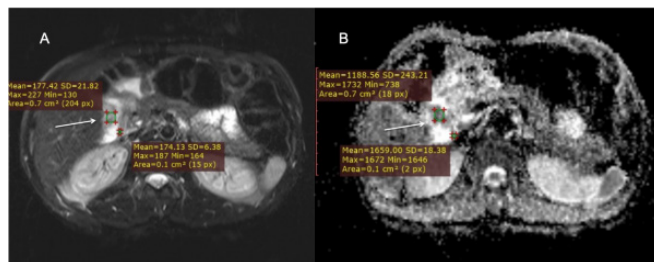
A 56 year-old patient with gastric adenocarcinoma. (a) Axial T2-weighted MRI image shows irregular hypo-intense wall thickening in the antrum (arrow). (b) Corresponding apparent diffusion coefficient (ADC) map of the patient. ROIs are copied and pasted from T2-weighted image. The ADC value of the thickened antrum (1.118 x10⁻³ mm²/s) is significantly lower than ADC values of the normal gastric wall (1.659 x10⁻³ mm²/s).
